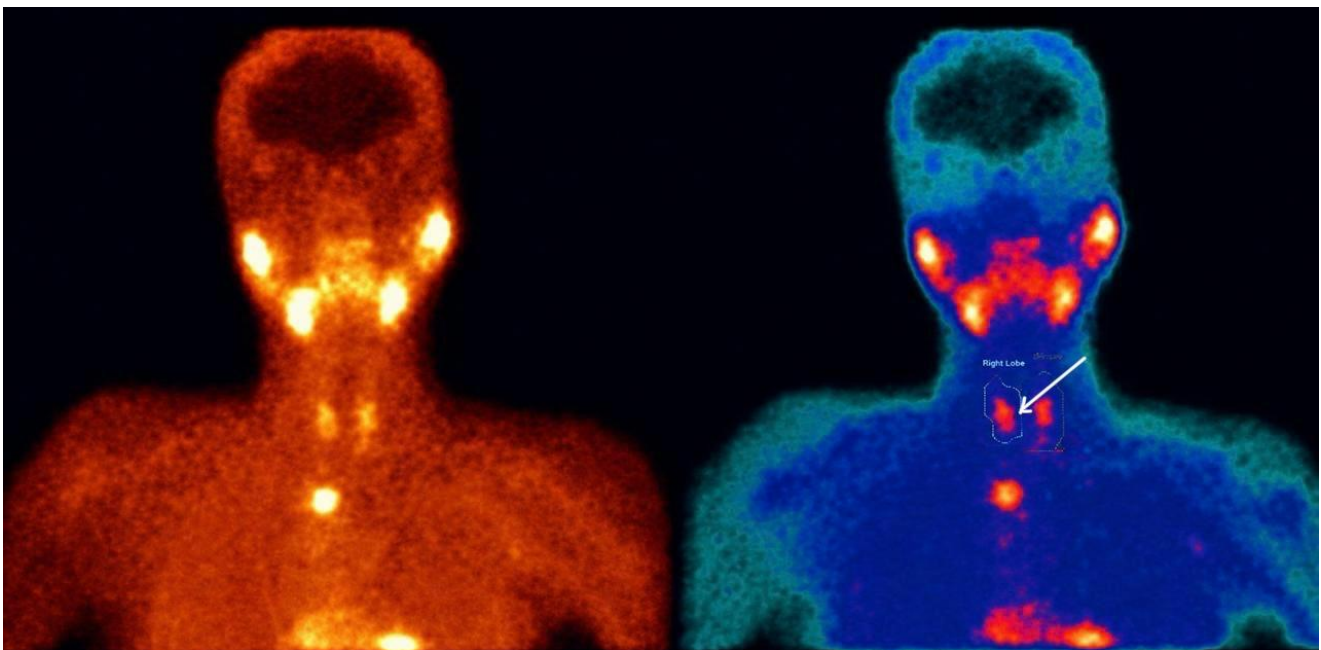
Parathyroid scintigraphy revealing a right parathyroid adenoma.
